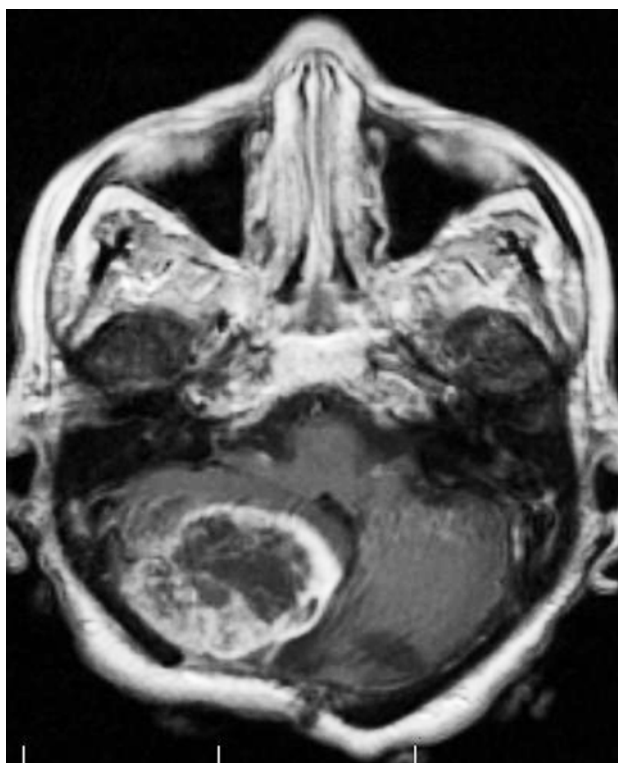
MRI of the brain demonstrates recurrent tumor of posterior fossa
